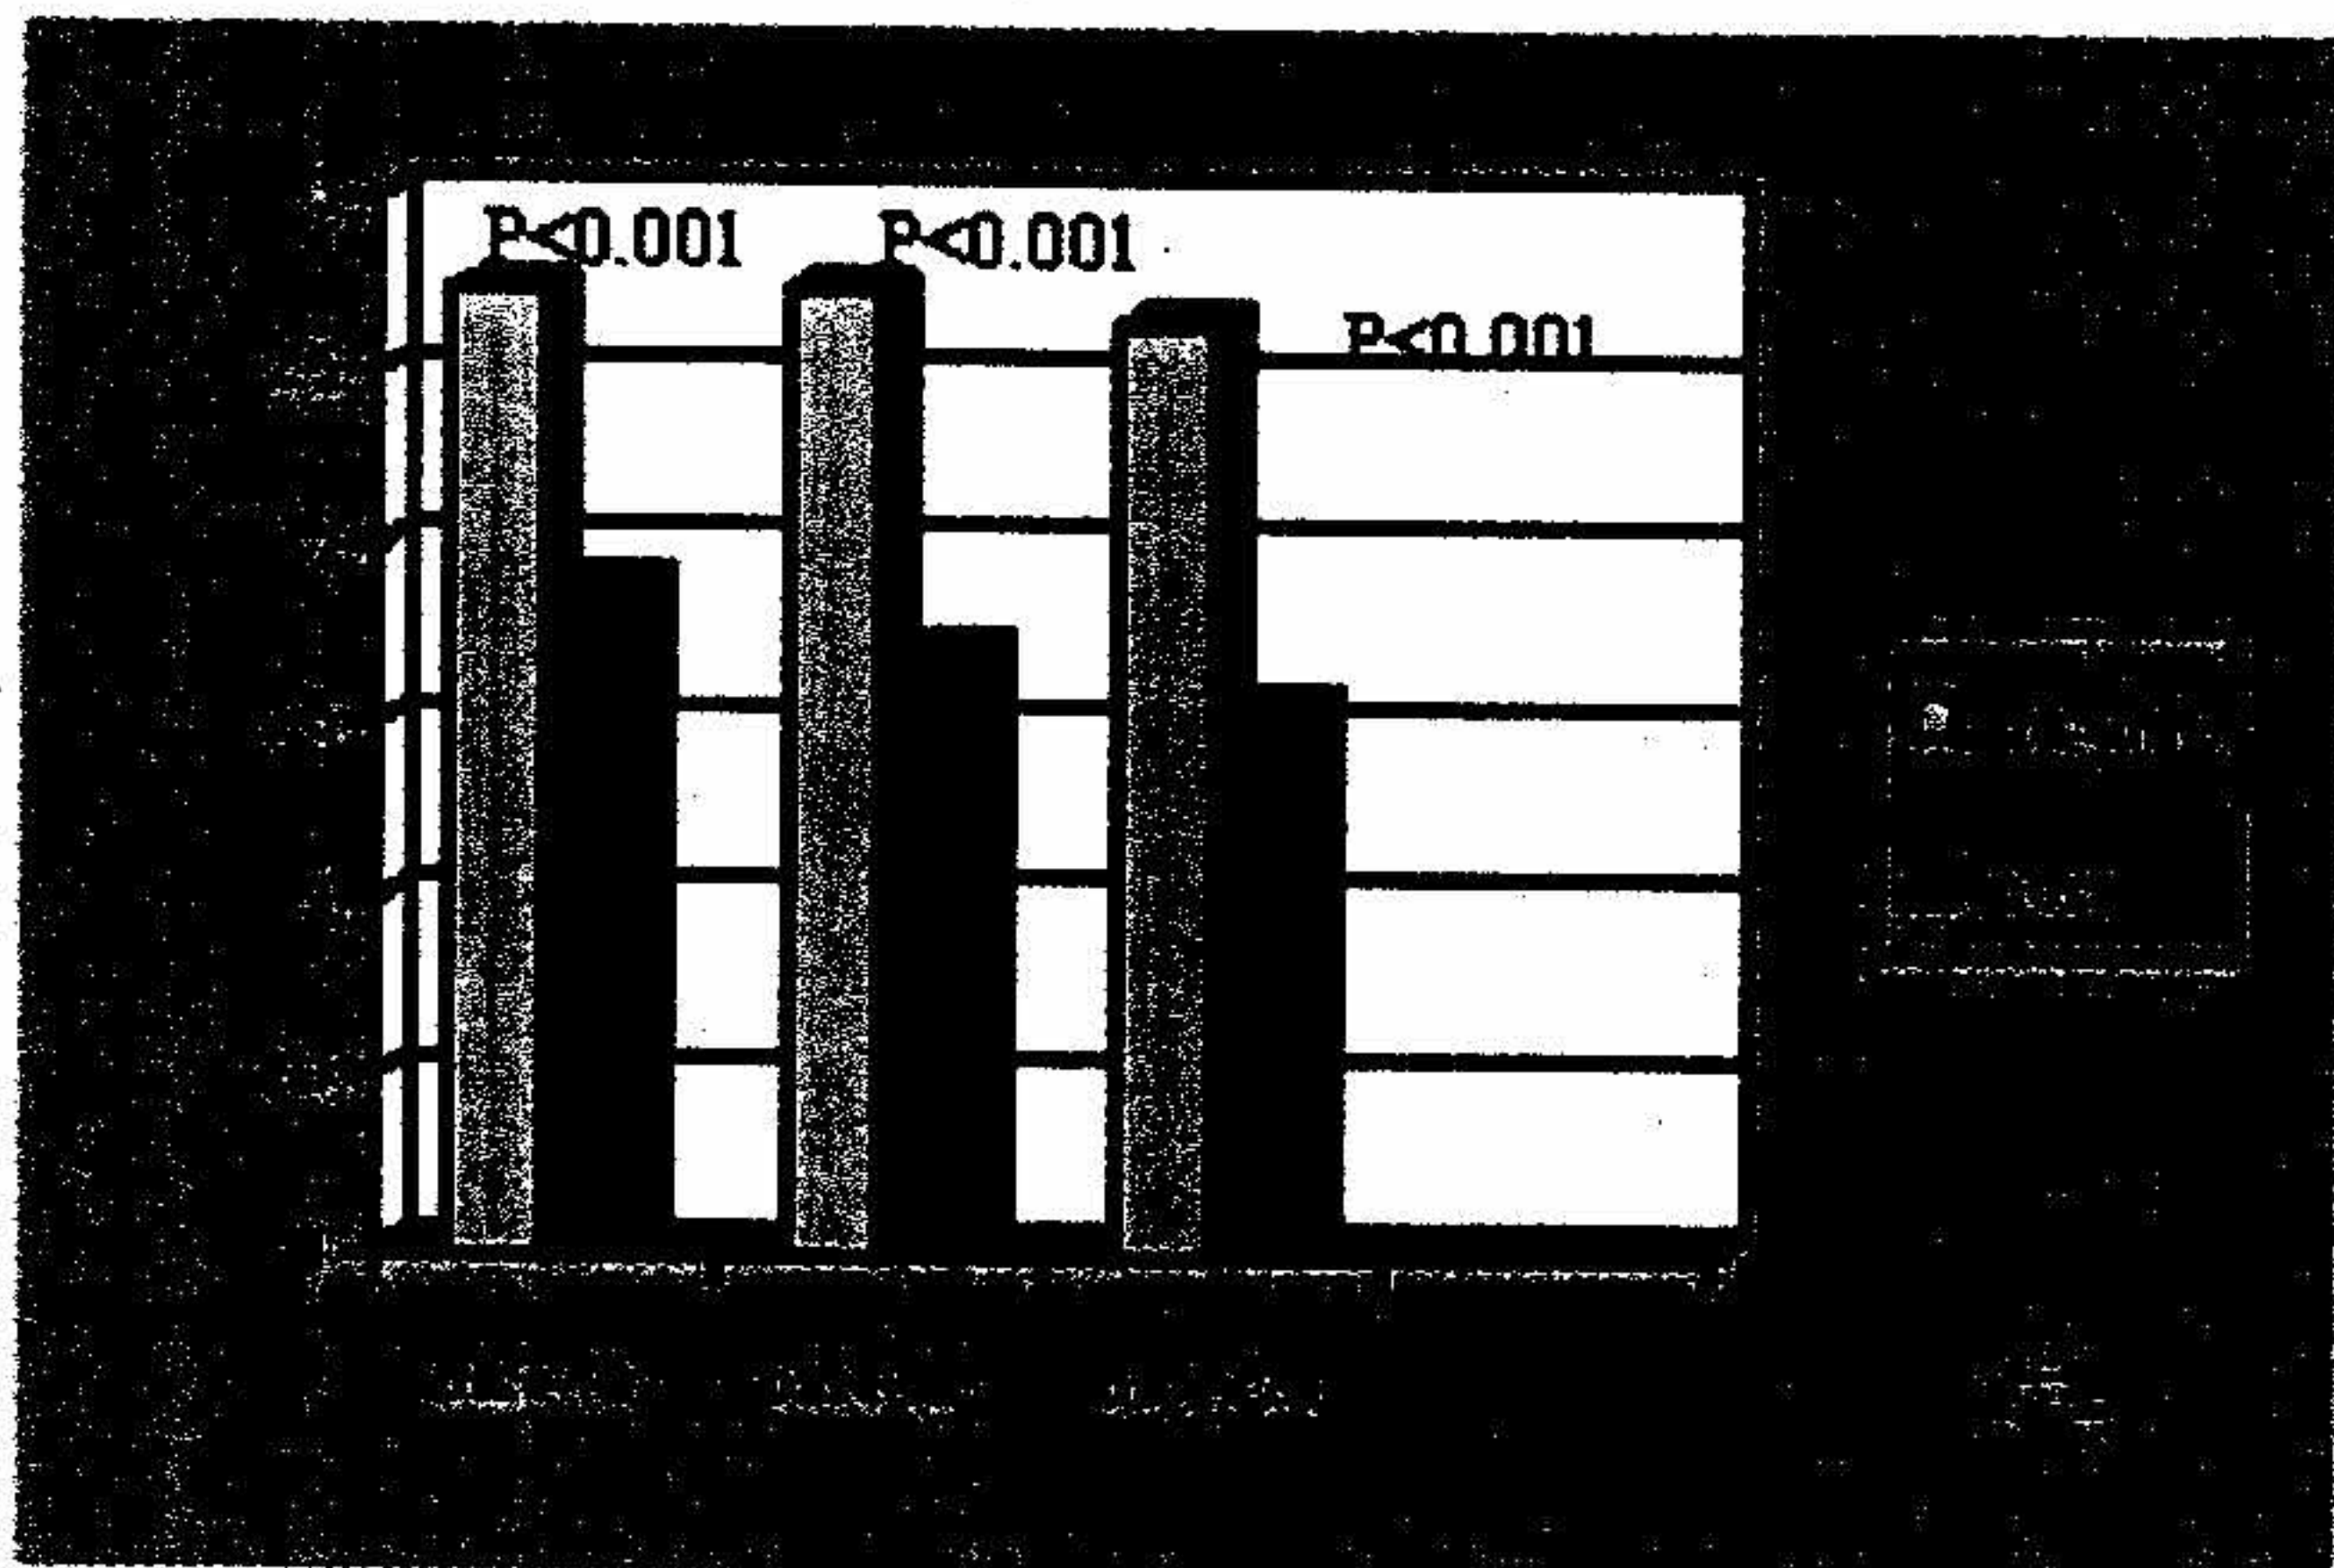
Mean of left ventricular ejection fraction (EF) by echo and by SPECT at baseline to post treatment 8-12 months follow-up
